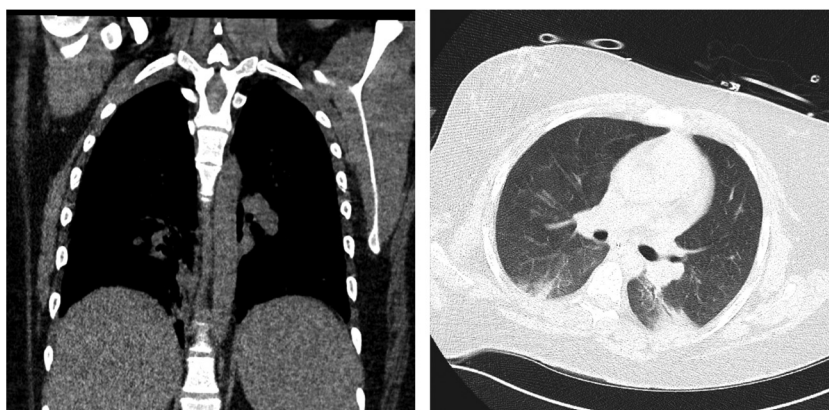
Chest CT scan follow up showing resolution of the bibasilar infiltrates. Left: coronal view; right: axial view.
